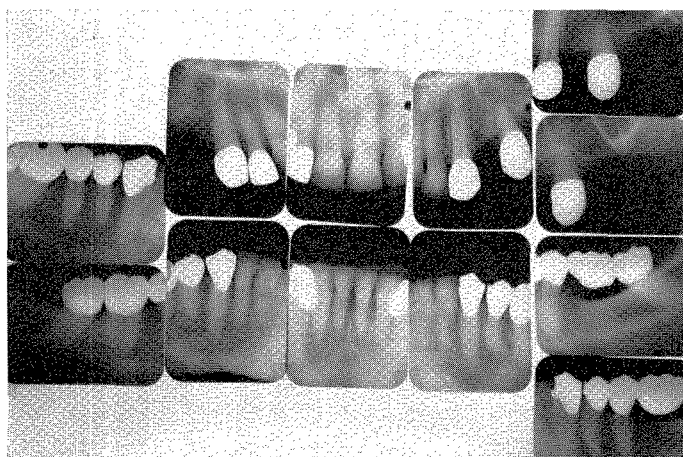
Roentgenograms taken in February, 1949, nearly four years after completion.
